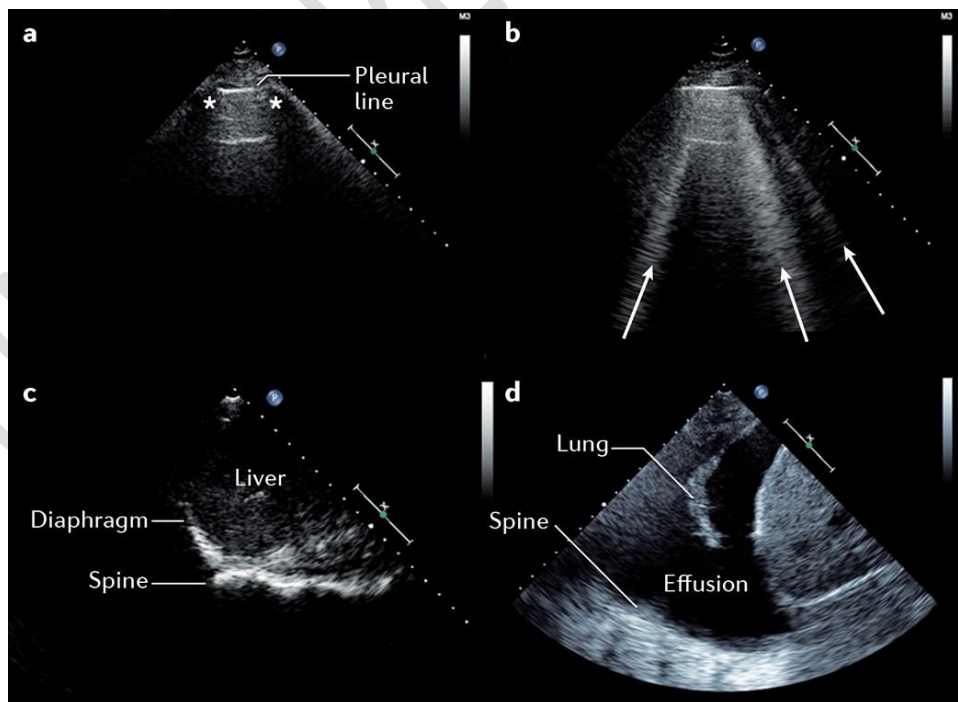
Echocardiography and Lung Ultrasonography for the Assessment and Management of Acute Heart Failure (16)
